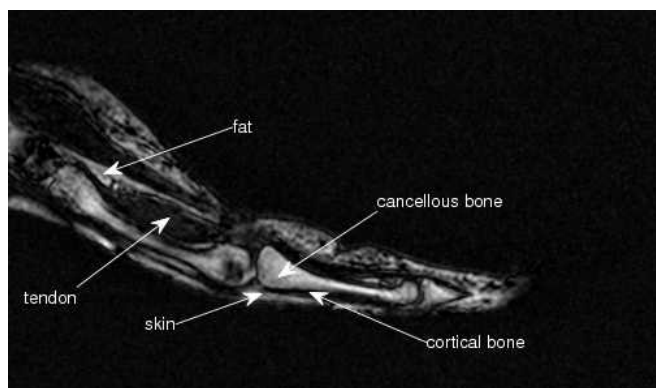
Example of an MRI image showing the type of tissues in the hand
